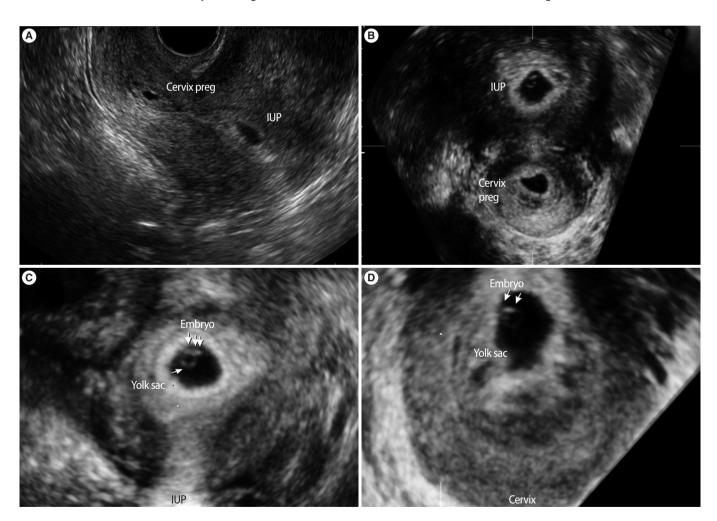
(A) Transvaginal ultrasonography showed a cervical and intrauterine pregnancy simultaneously at 4 weeks+5 days of gestation. (B) Preoperative follow-up imaging at 5 weeks+2 days of gestation. Two gestational sacs were confirmed. (C) One sac in the uterine cavity, measuring 13.5 mm with a live fetus (crown-rump length measuring 3 mm with fetal heartbeat). (D) Another sac in the uterine cervix, measuring 9.6 mm with yolk sac and fetal pole and equivocal fetal heart tones. IUP, intrauterine pregnancy; cervix preg, cervical pregnancy.
